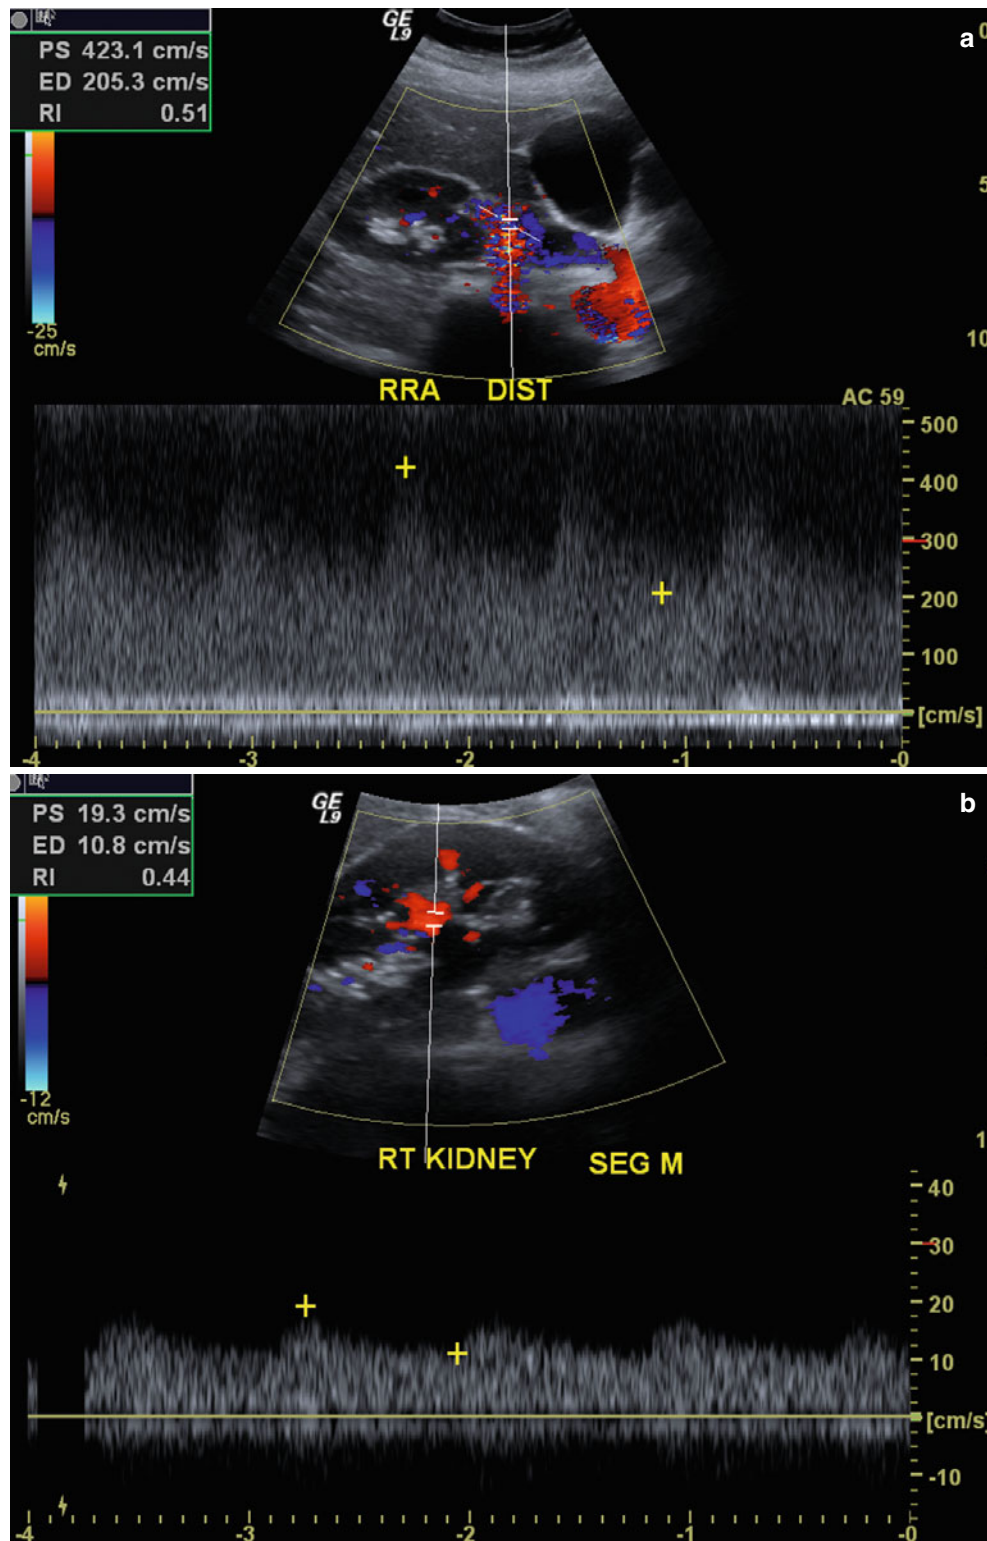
Renal artery stenosis. Spectral Doppler sonographic images of the right renal artery, (a) at the level of a high-grade stenosis in the distal renal artery and (b) at the level of the segmental arteries, distal to the stenosis. (a, b) Abnormally high velocity is demonstrated at the level of the renal artery stenosis, while the arterial waveforms distal to the stenosis (b) show an abnormally delayed systolic upstroke with low amplitude (“tardus parvus”) with corresponding low velocity. (c)
